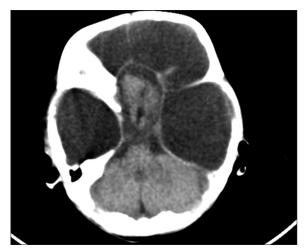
Non-contrast axial CT image shows relatively normal cerebellar hemispheres, brainstem, and bilateral thalami
